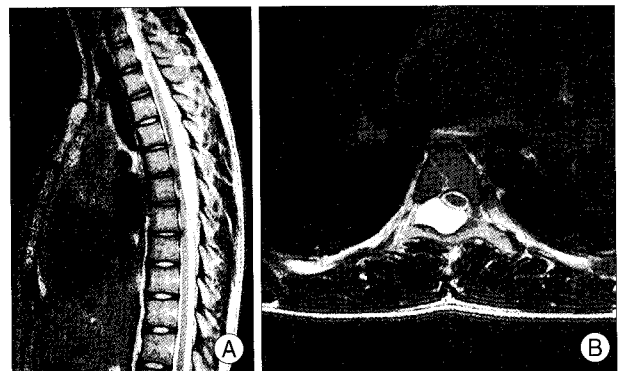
Preoperative MRI. A : Sagittal MRI showing the extent of the tumor. B : Axial MRI showing the extent of the tumor, compressing the spinal cord to the left side.
